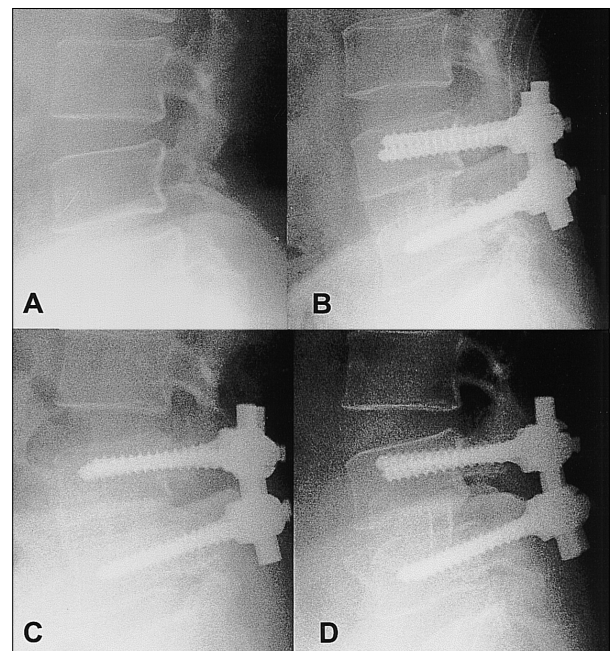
A. Preoperative lateral radiography of a 37-year-old woman with spondylolytic spondylolisthesis shows anterior slip of L4 and narrowing of the L4-5 disc space. B. Postoperative lateral radiography of a 40-year-old woman treated with anterior interbody fusion with pedicle screws shows good reduction and the restoration of disc space. C. Postoperative 6-month follow-up lateral radiography of the lumbar spine shows a slight loss of reduction. However, disc space height was well preserved. D. Postoperative 24-month follow-up lateral radiography of the lumbar spine shows good fusion of L4-5 and a well preserved disc space height.
